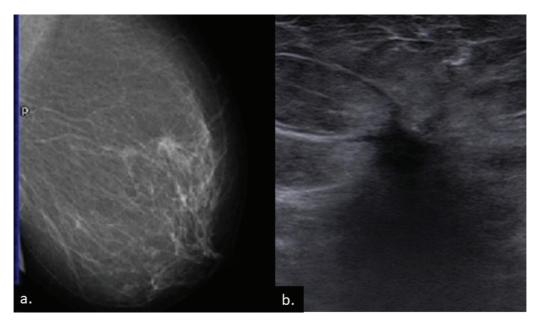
A small, fat-surrounded, spiculated, ill-defined, peripherally located nodule is seen on mammogram (a). Ultrasound (b) shows a small tubular carcinoma, iso- to hypoechoic with spiculated/angular margin surrounded by thick echogenic halo. The lesion is taller than wider with intense posterior shadowing.
